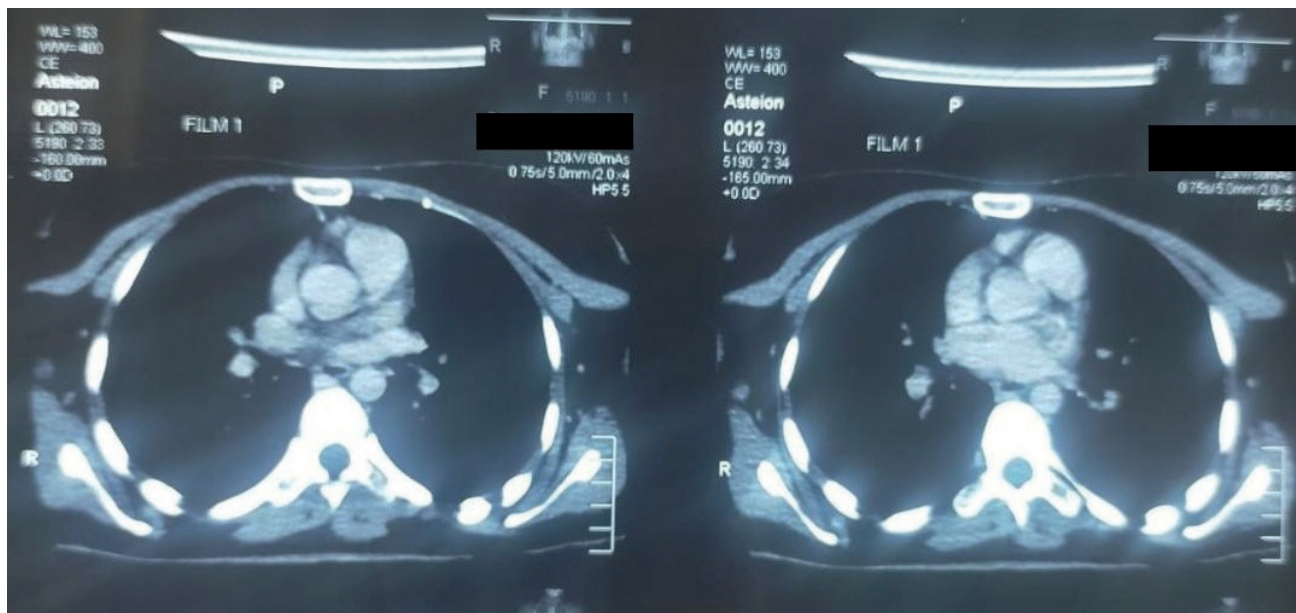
CT of chest with contrast showing no evidence of residual thyroid tissue and complete regression of pulmonary metastasis.
